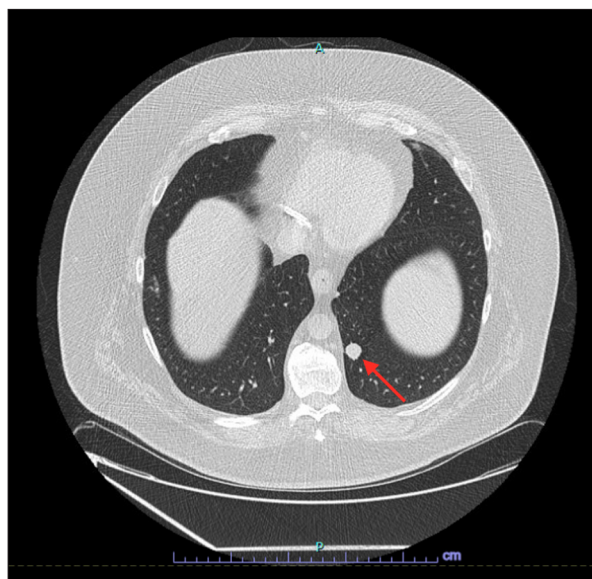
Low-dose computed tomography scan demonstrating a 1.6-cm left lower lobe pulmonary nodule (arrow).
